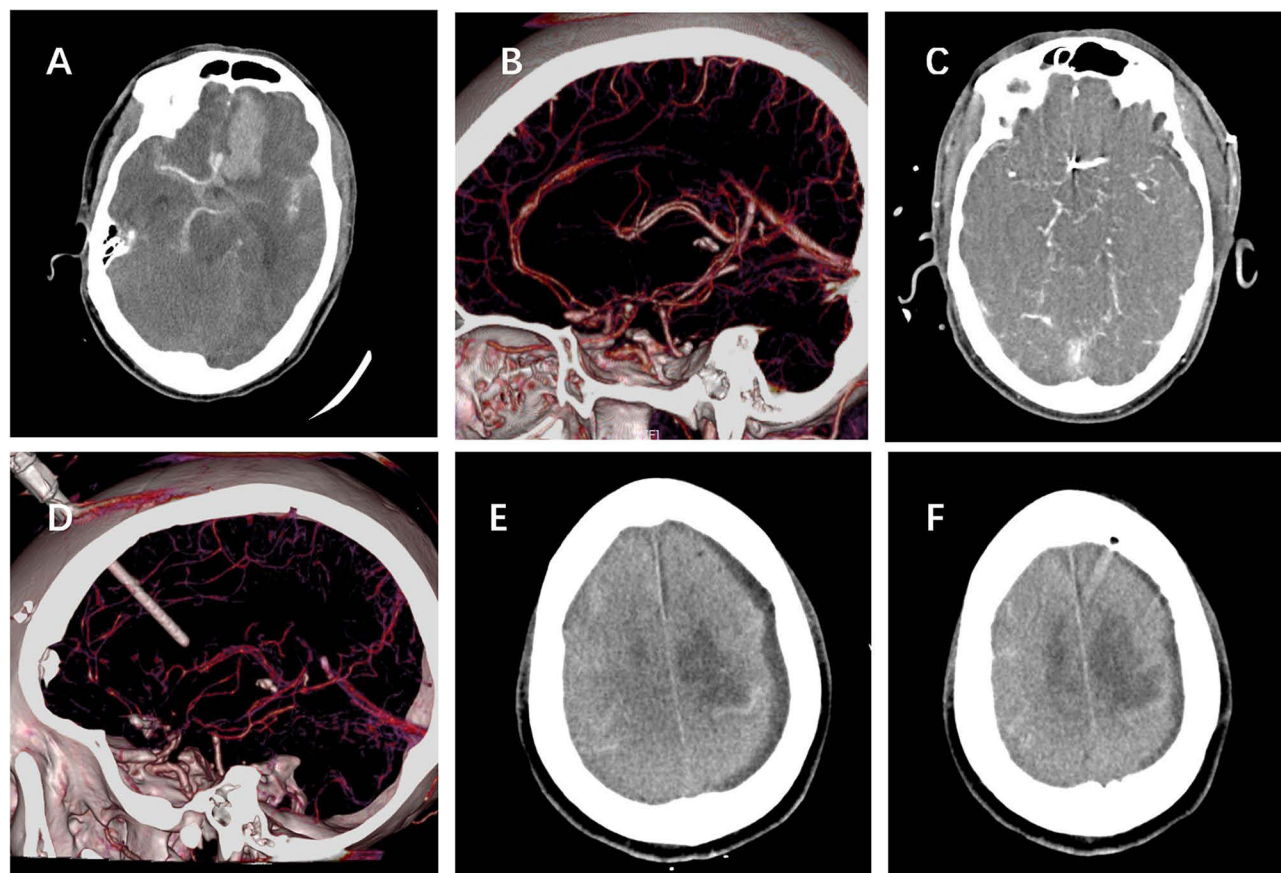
(A and B): CTA demonstrated a ruptured AcomA aneurysm with intracerebral hematoma (20.0mL). (C): The aneurysm was clipped and hematoma was removed. (D–F): Cerebral infarction was found in the bilateral frontal lobe 7 days after the surgery for the reason of vasospasm.
